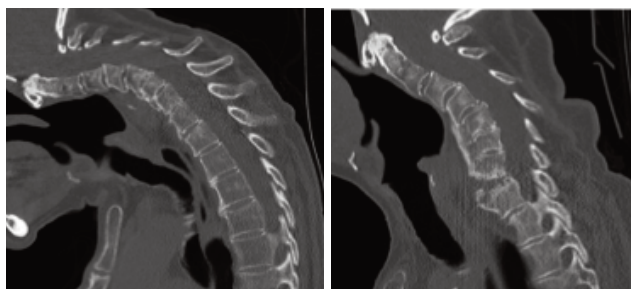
Post-operative radiographs demonstrating surgical procedure in patient 4.
